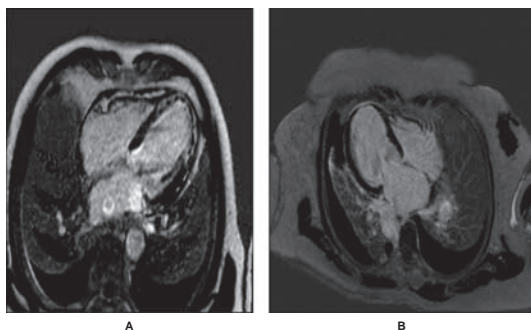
Late gadolinium-enhanced MRI: Both patients A and B have extensive akinesia in LAD territory; however, patient A has more extensive scar ($> 50\%$ in multiple segments) than patient B and is less likely to have LV function recovery post revascularization.
